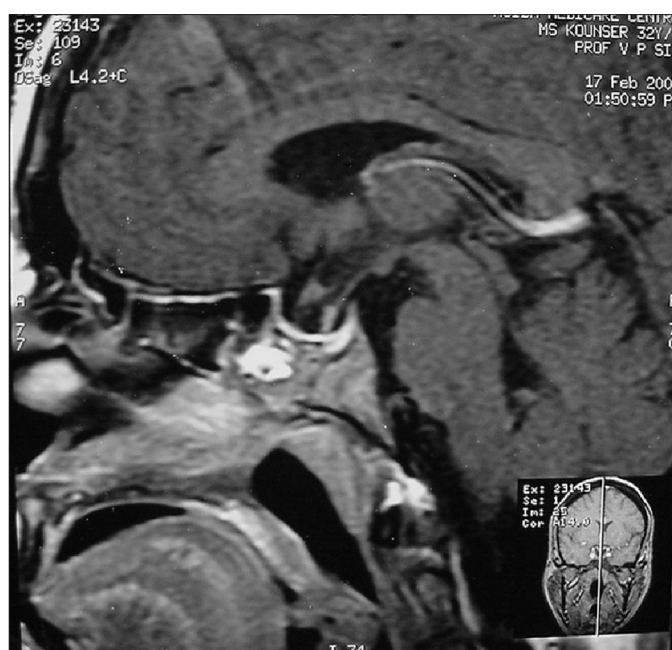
Postoperative MRI (sagittal section) showing empty sella with prominent pituitary stalk reaching the sellar base
